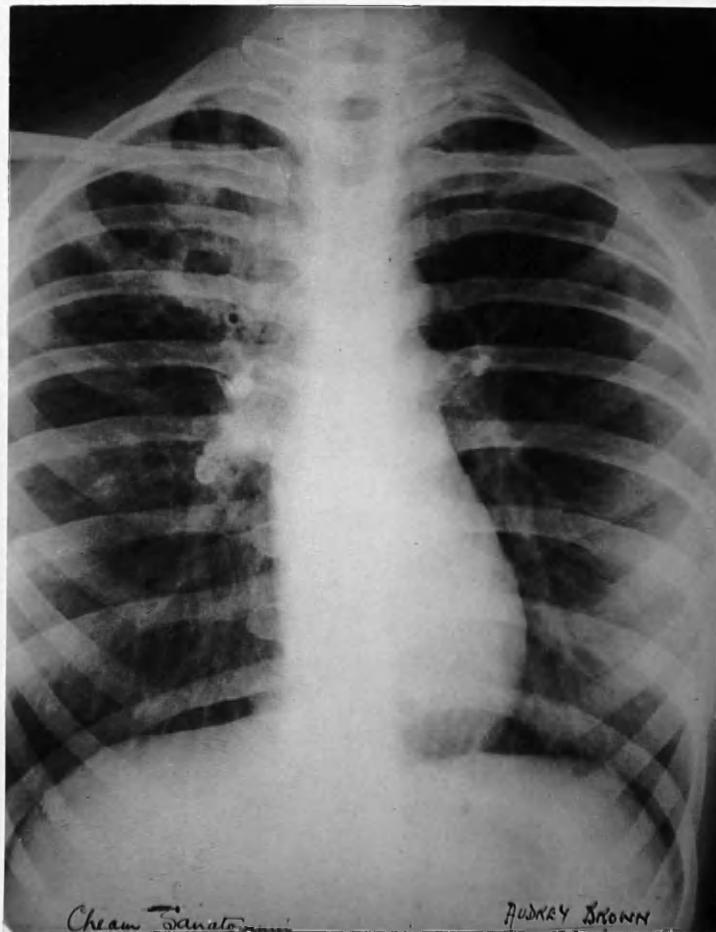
Radiograph of 13.9.49.
